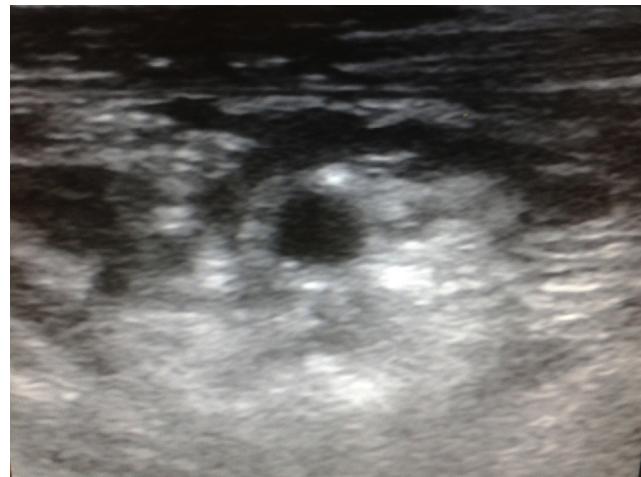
Ultrasound image of the brachial plexus at the infraclavicular level showing the distribution of the local anaesthetic to the lateral, posterior and medial fascicles.
